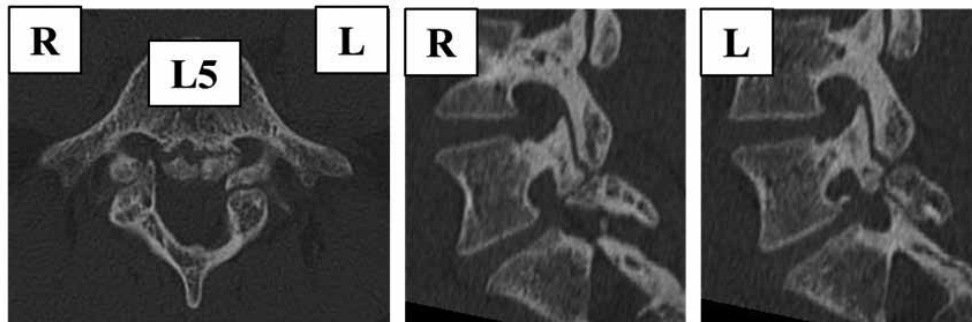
Preoperative computed tomography scans show bilateral L5 spondylolysis in the terminal stage and an apophyseal ring fracture at the endplate.
